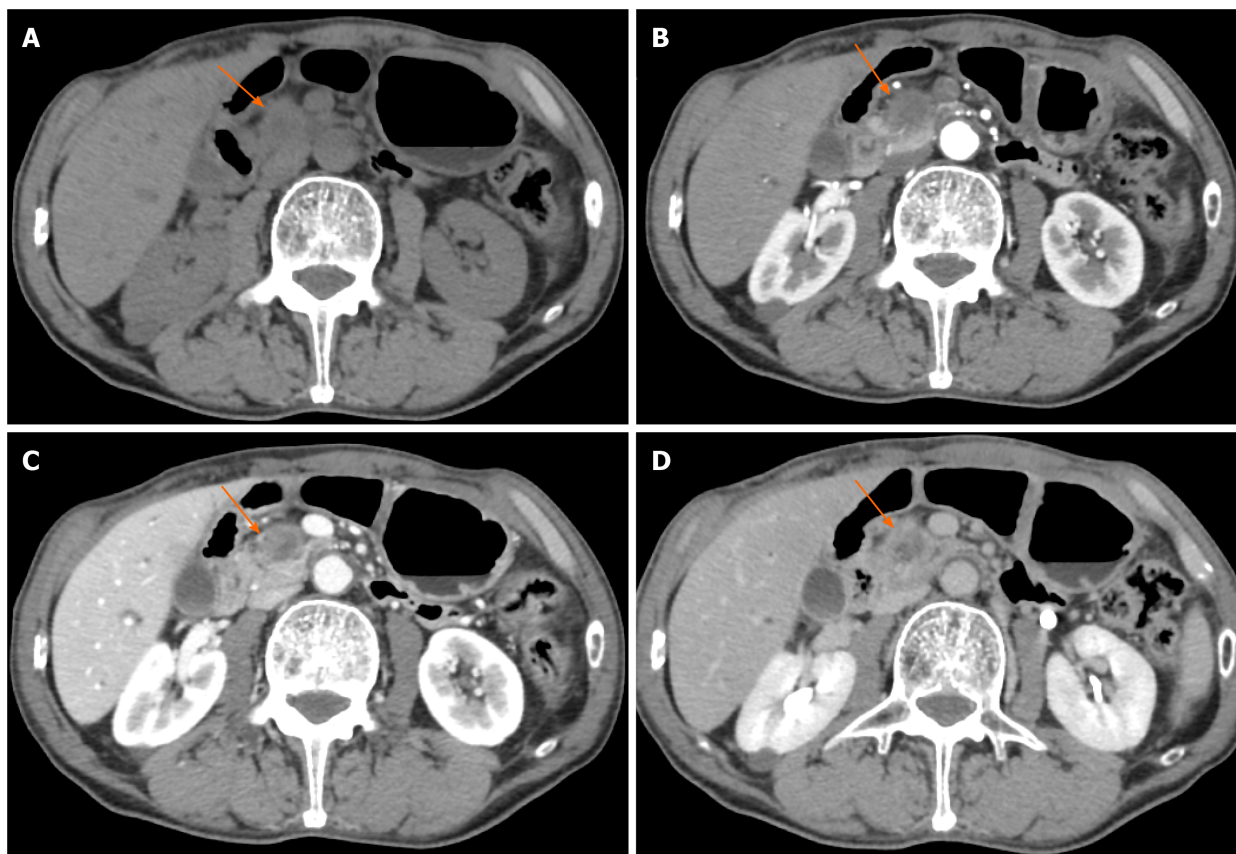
Typical CT features of pancreatic head carcinoma in a 73-year-old male patient. A: On noncontrast CT imaging a slightly low-density mass (arrow) in the pancreatic head area was identified; B–D: On contrast CT images, the tumor shows an avascular tumor with a lower density than normal pancreatic parenchyma on arterial phase (B), venous phase (C), and delay phase (D). CT: Computed tomography.
